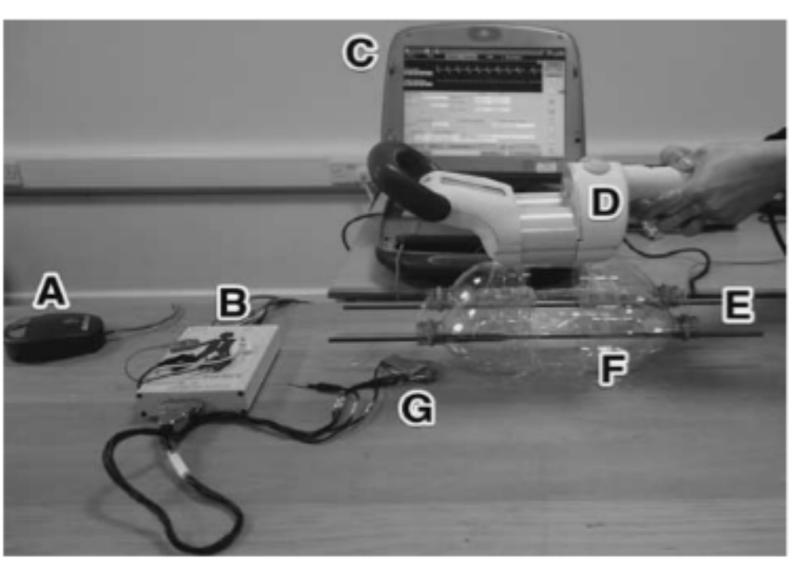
Experiment setup (A-pacemaker magnet; B- virtual patient; C—cardiac monitor; D—external remote con- troller for growing rods; F—jig; G—magnetic resonance imaging-compatible pacemaker).
